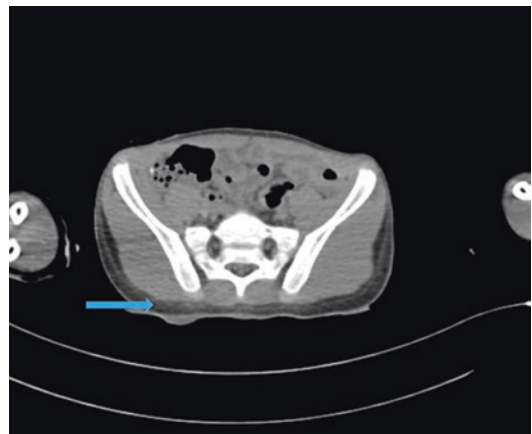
Dorsal gravitational hypostasis (arrow) with fluid collection at CT scan image
